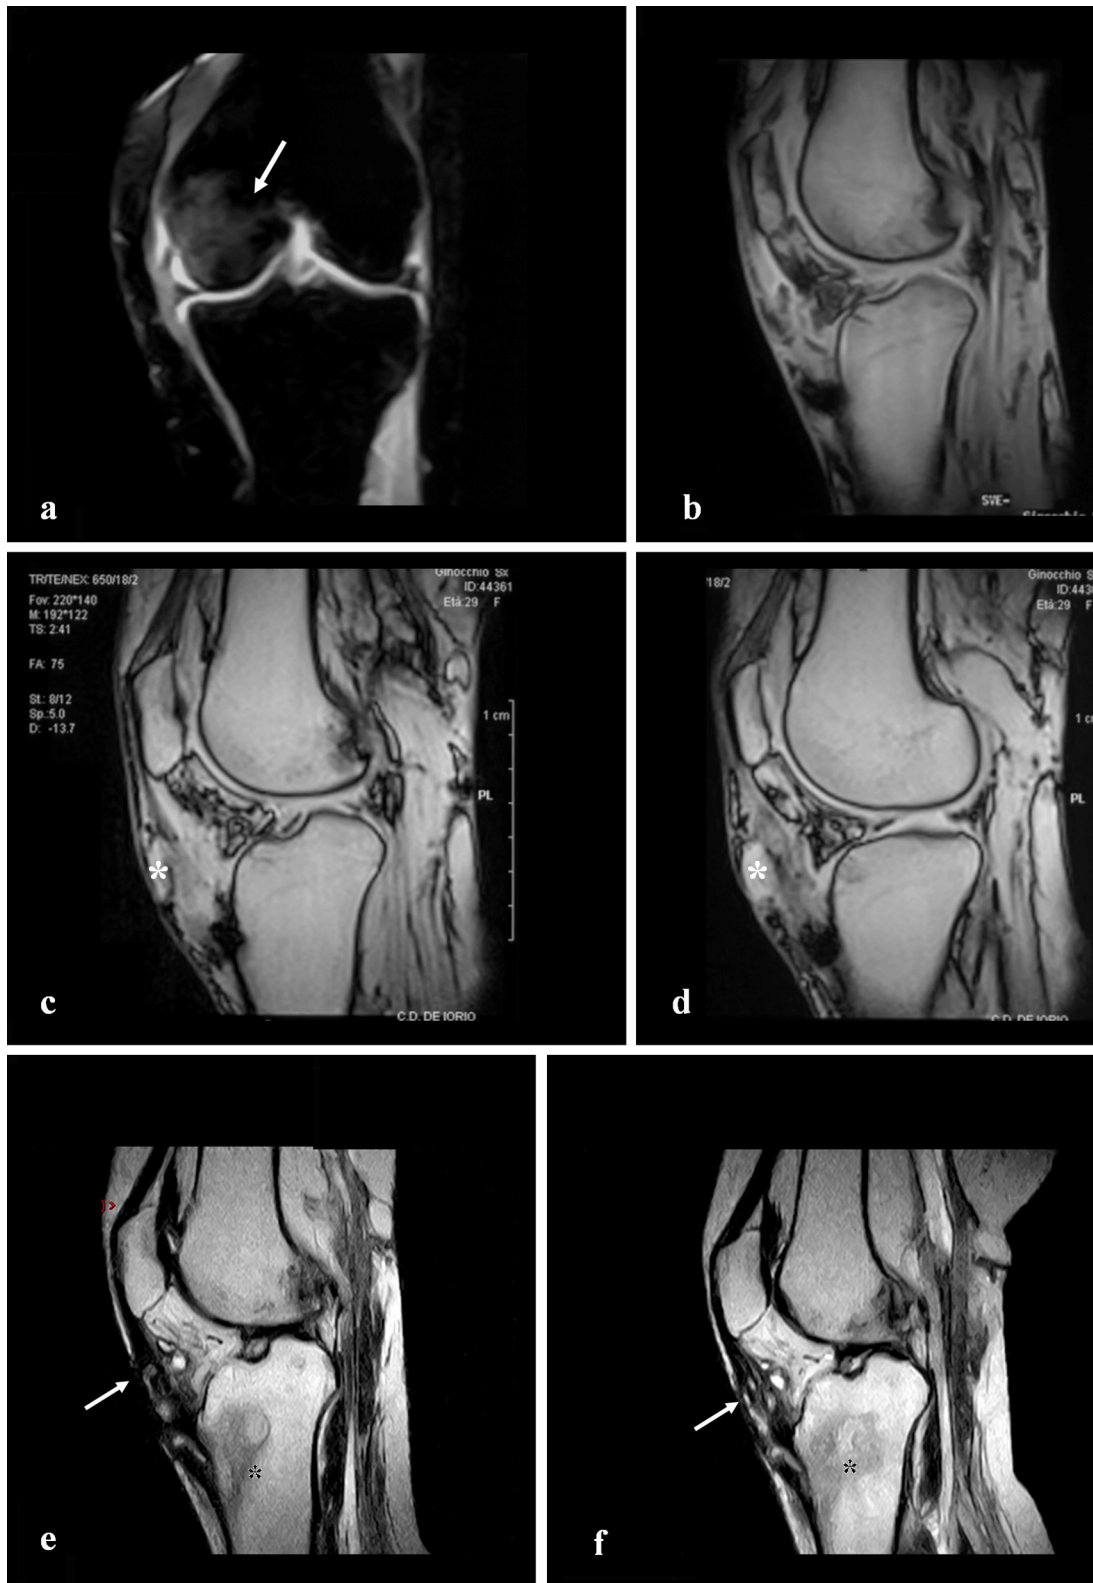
Initial MRI 4 months after the tsunami. Coronal T2-weighted fat-suppressed image showing a medial femoral condyle abnormality (white arrow) (a). Sagittal MRI showing aspecific abnormalities in the anterior part of the knee (b). MRI performed 1 year later showing a liquid cyst adhering to the surface of the patellar tendon (asterisk) (c and d). Sagittal MRI of the left knee performed 4 years (e) and 4.5 years (f) after the trauma showing a progressive signal alteration of the tibial cancellous bone in the meta-epiphyseal region (black asterisk) associated with an abnormal cystic lesion (grains) in the soft tissue (white arrow).
